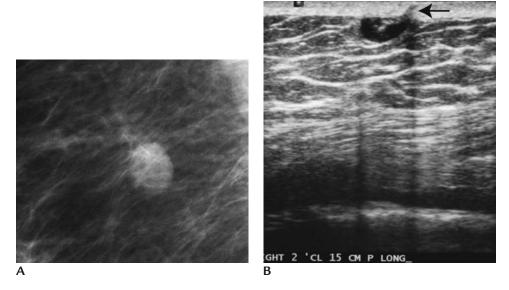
Sebaceous cyst. (A) Spot compression view in the mediolateral oblique projection demonstrating an oval iso-dense mass with partially indistinct margins in the upper inner quadrant of the right breast (craniocaudal view not shown). (B) On physical examination, a mass is palpated in the upper inner quadrant of the right breast posteriorly. On palpation, the lesion moves with the skin (e.g., cannot slide skin over the lesion as can be done when a mass is in the breast). An oval hypoechoic mass with well-circumscribed margins is imaged on ultrasound corresponding to the palpable finding. Although not always apparent, a tract to the skin (*arrow*) is seen in this patient as a hypoechoic tubular structure extending from the mass through a portion of the dermis. Thin edge shadows are present.
